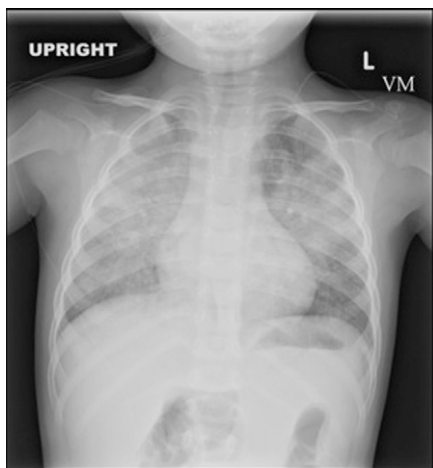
Chest radiograph on initial presentation. Confluent opacities are seen within the mid-lungs bilaterally, sparing the apices and bases.
